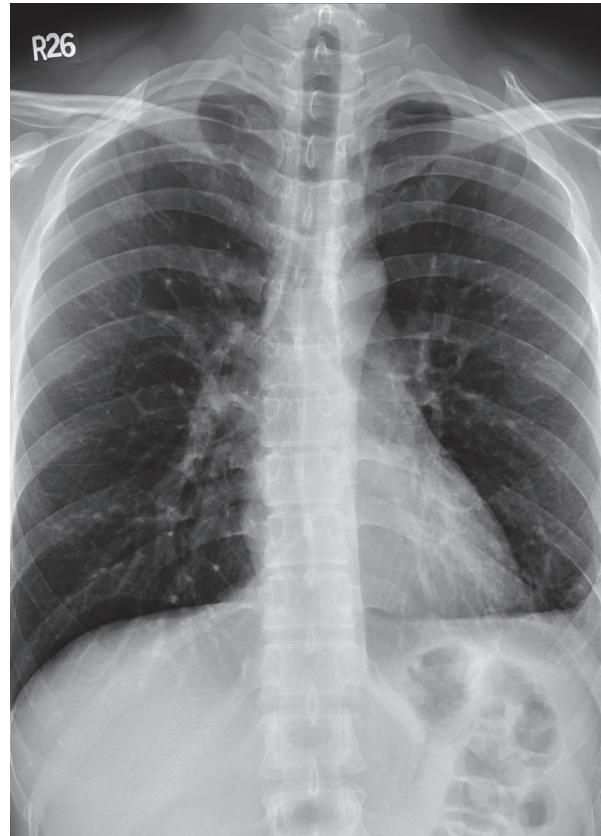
Chest X-ray showed resolution of the left hemopneumothorax of the previous trauma.
